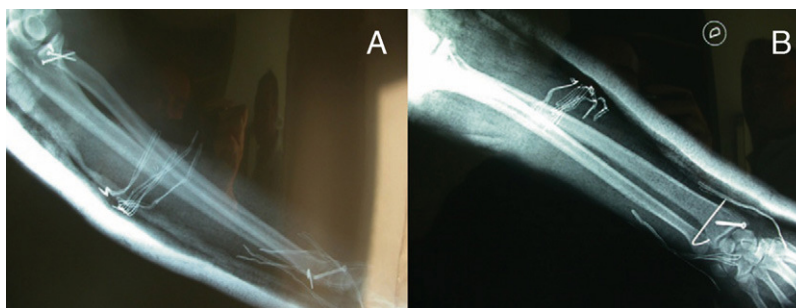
Post-intervention radiological image of the upper right limb. (A) AP X-ray; (B) lateral X-ray.
